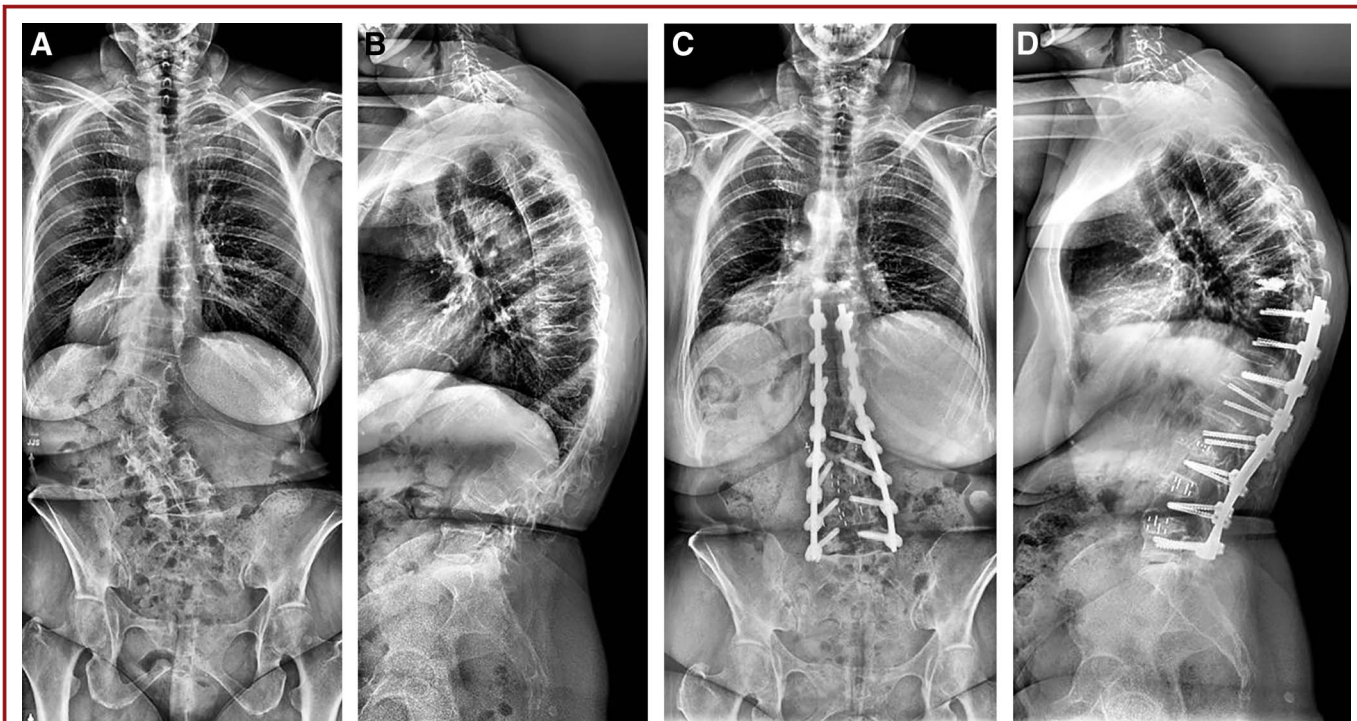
A and B, baseline anteroposterior and lateral scoliosis x-rays. C and D, anteroposterior and lateral scoliosis x-rays at the 2-year follow-up visit showing kyphoplasty performed for proximal junctional kyphosis.
